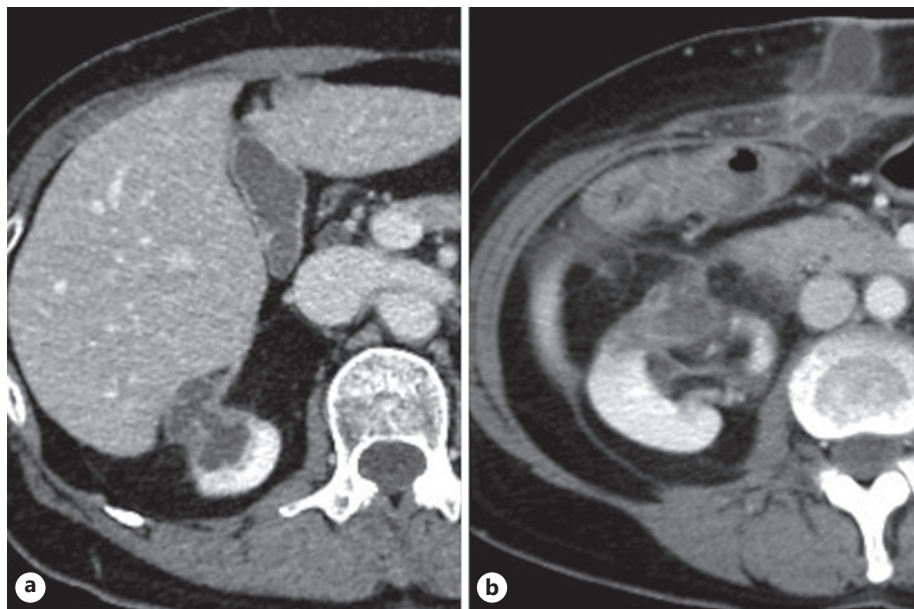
a Contrast-enhanced computed tomography images showing a mass lesion in the upper pole of right kidney protruding toward the perirenal fat, which was later diagnosed pathologically as crizotinib-associated renal cysts (CARCs). b CARC-like aseptic abscesses along the abdominal wall near the surgical wound appeared after the readministration of crizotinib. The figure also shows similar lesions remaining in the resected right kidney.
